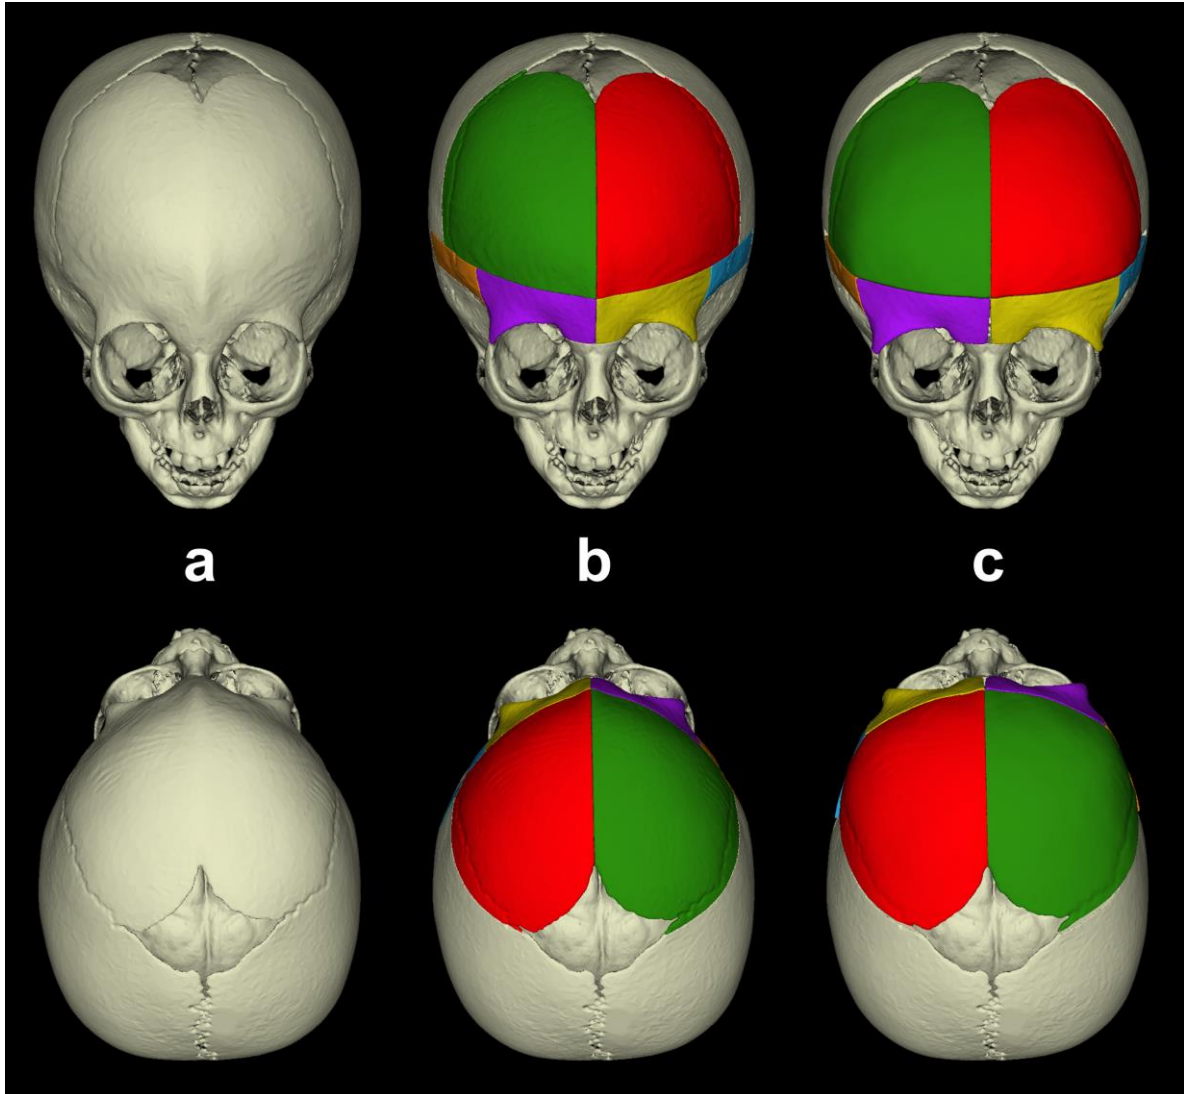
VSP of open cranial vault remodeling for correction of metopic craniosynostosis: (a) 3D model of the cranium obtained from preoperative CT scan, (b) definition of osteotomy lines and fragments, and (c) reconfiguration of bone fragments to achieve desired postoperative cranial shape.
